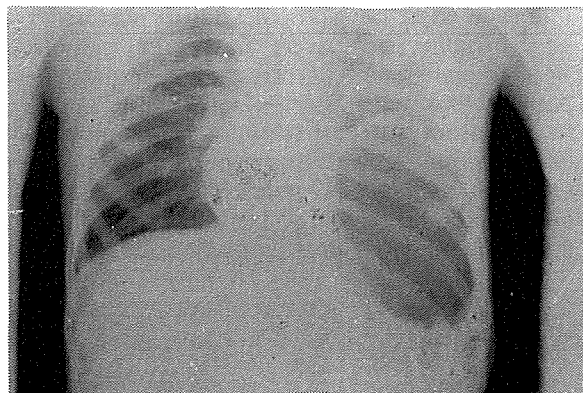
Chest X-Ray of young boy with a ruptured (L) hemidiaphragm and herniation of the stomach into the chest cavity.
